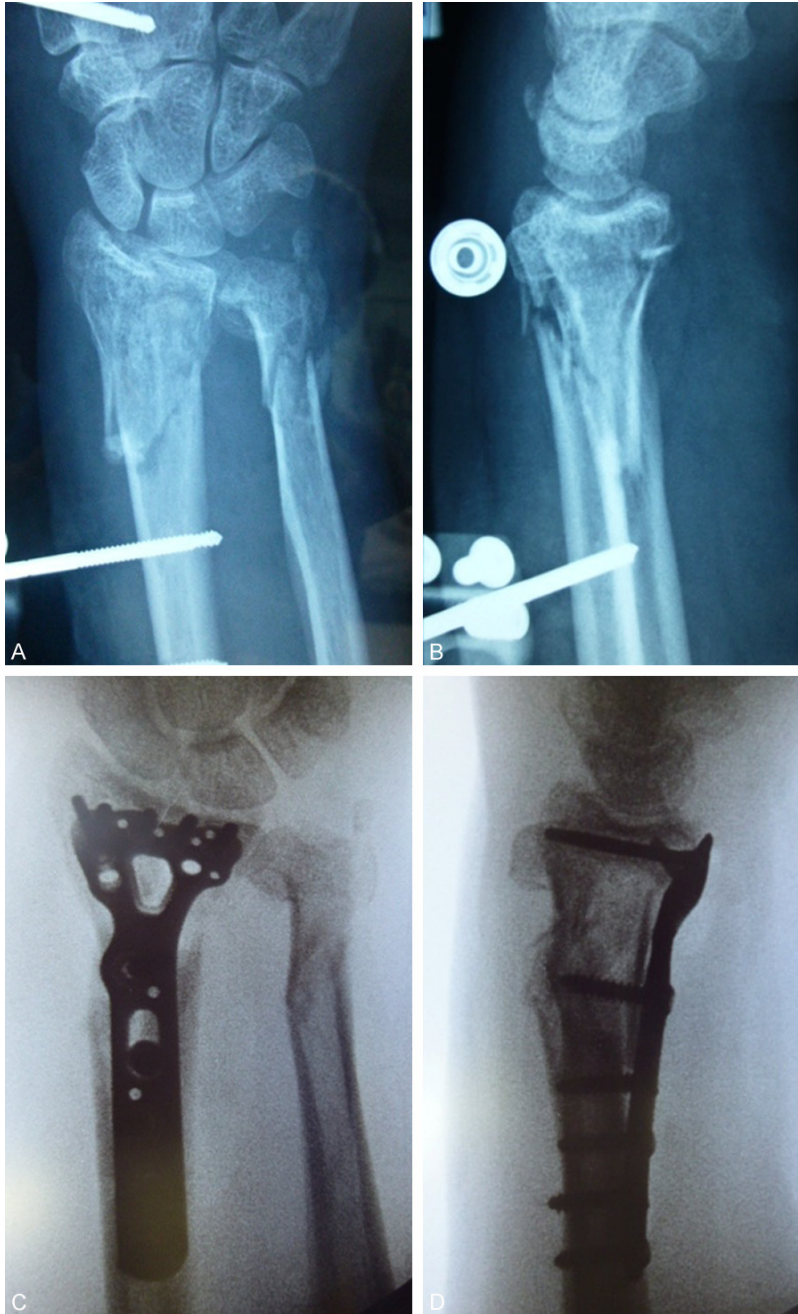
Conservative treatment of distal radius fracture-associated distal ulna fractures. A: Preoperative frontal view on plain radiography. The patient was a 73-year-old female with left distal radius and ulna fractures that occurred due to a fall. The distal radius fracture was type C3 on the AO classification, and the distal ulna fracture was type 3 on the Biyani classification. B: Preoperative lateral view on plain radiography. Comminuted fractures were noted at the distal ends of the radius and ulna. C: Frontal view of the radius on plain radiography after osteosynthesis. D: Lateral view of the radius on plain radiography after osteosynthesis. The DRUJ alignment was favorable, and no intervention was applied to the distal ulna fracture.
